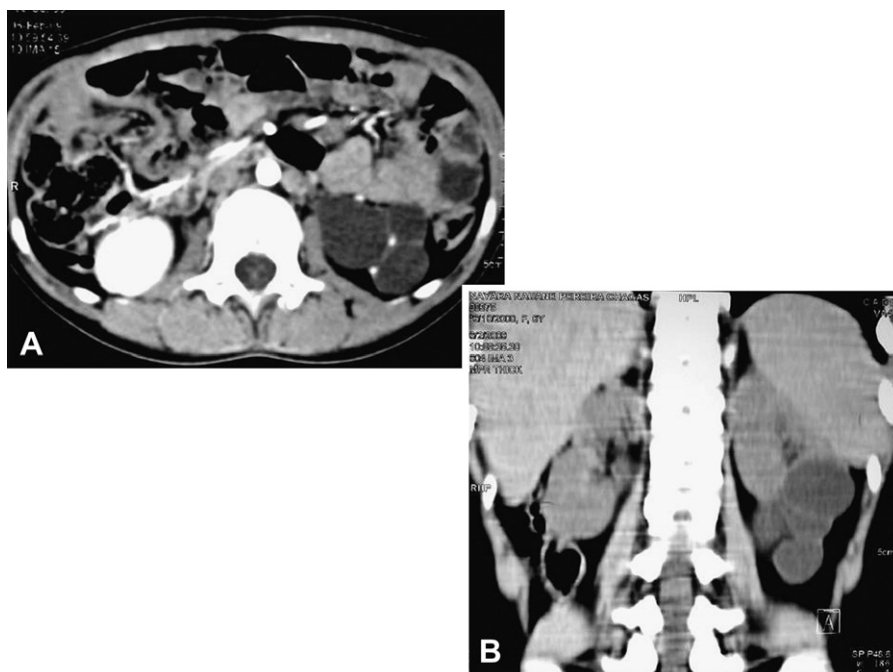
Non-contrast CT scan identifies clearly the cysts on the left lower pole.
